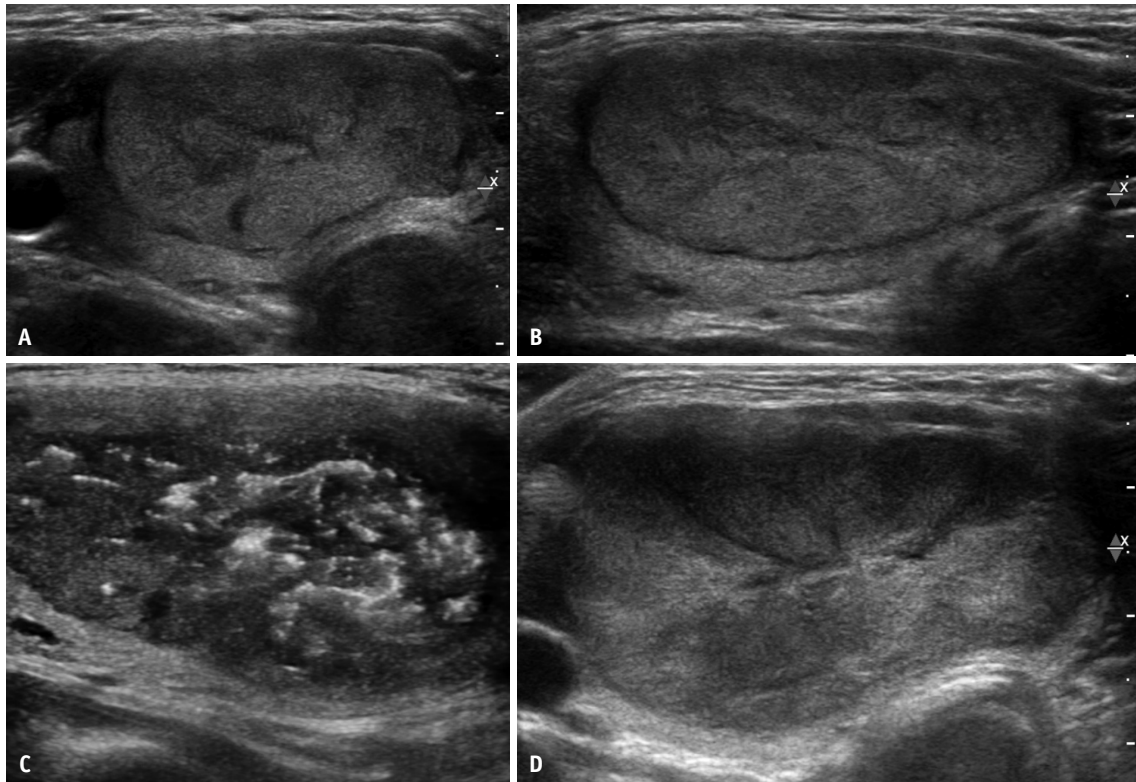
A 21-year-old female patient with minimally invasive follicular thyroid carcinoma (FTC) in surgery after radiofrequency ablation (RFA). The patient had a 4.6-cm sized symptomatic large thyroid nodule (A: transverse ultrasound [US] image, B: longitudinal US image) located in the right thyroid gland, classified as low suspicion on US and confirmed as benign using two fine-needle aspirations and treated with RFA (C). One year after RFA, the nodule size increased to 5.0 cm, appeared hypoechoic, and revealed hypervascularity (D). Pathology report after right lobectomy revealed minimally invasive FTC.
